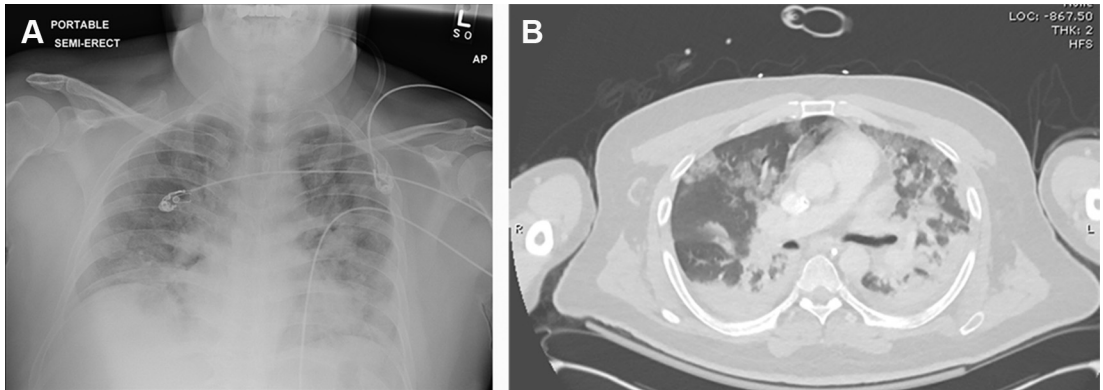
Chest radiograph and computed tomography of the chest of a 42-year-old male patient admitted with pneumonia and 2009 H1N1 influenza infection leading to acute respiratory failure. Chest radiograph (A) reveals diffuse consolidation, and the computed tomography of the chest (B) reveals bilateral patchy ground-glass opacities and dense consolidation in the dorsal areas.
